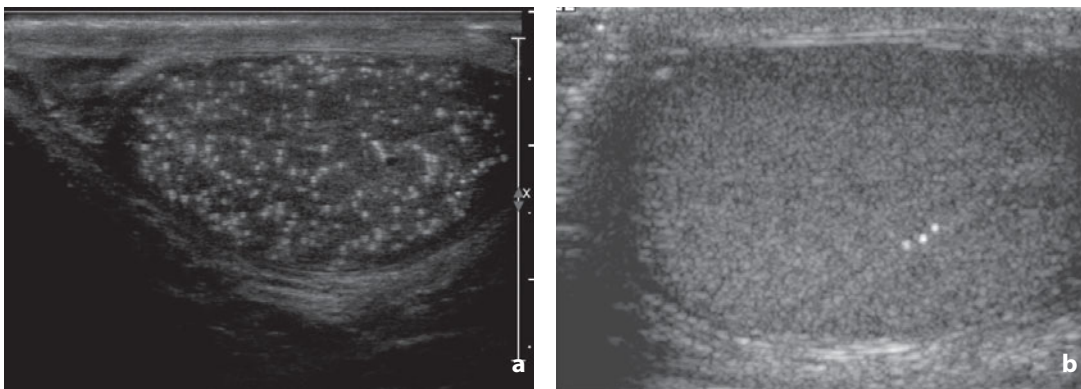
Testicular microlithiasis. Sonograms show the presence of small hyperechoic foci with no acoustic shadow and without associated structural anomalies of the surrounding parenchyma. In a the alteration appears diffuse, while in b the microlithiasis is located in the center of the testicle, with three small hyperechoic foci
